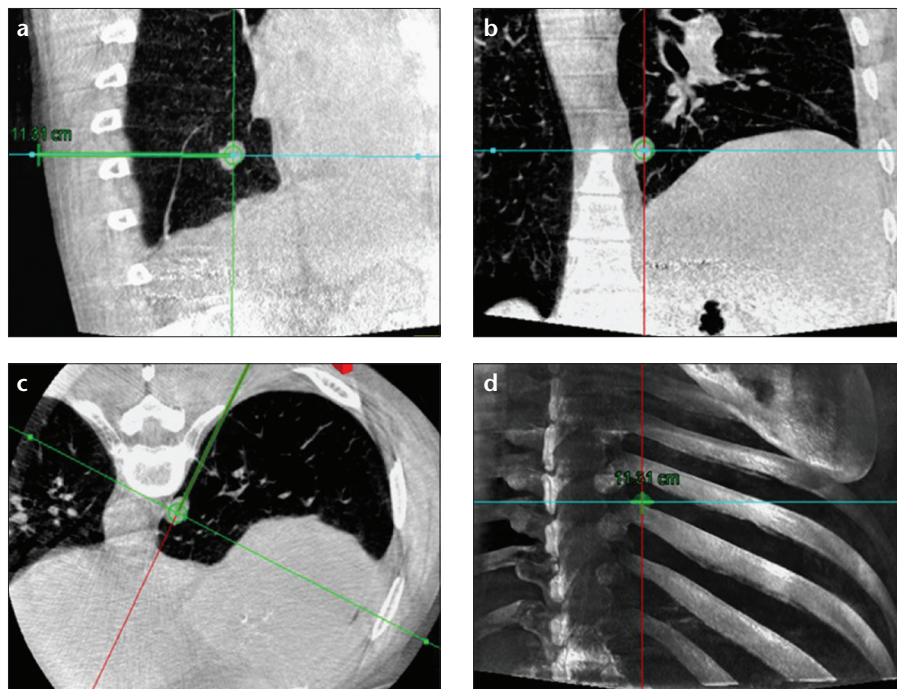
a–d. CBCT orthogonal multiplanar images with graphics showing planned needle path (green line) into target lesion (green circle) (a–c). The cross indicates the skin entry site and the circle indicates the target lesion site. The needle position relative to the anatomical structures is displayed in 3D using volume rendering technique (d).
